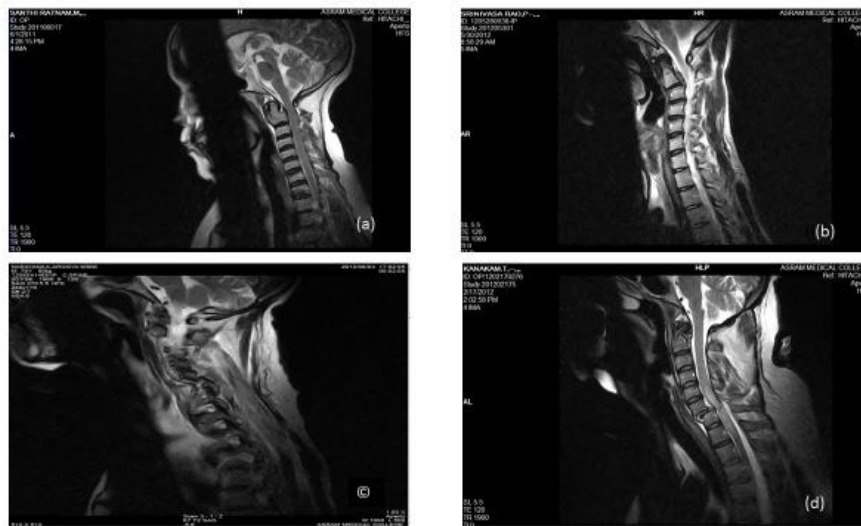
(a)-T2-weighted sagittal image of cervical spine showing fracture of odontoid fracture.
